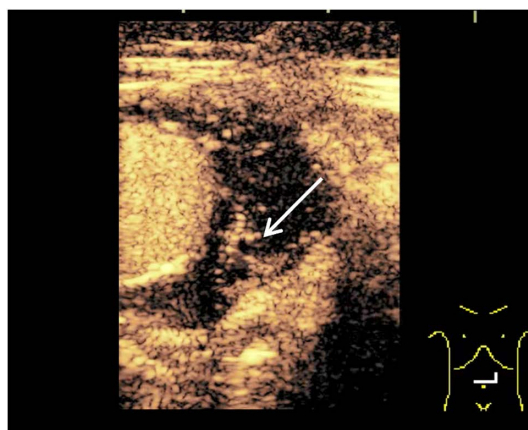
Contrast-enhanced ultrasound image of the slow endoleak case at 7 min after injection of the contrast material. A larger amount of the contrast material is seen in the aneurysm sac as compared with 2 min, which suggests a slow endoleak.
